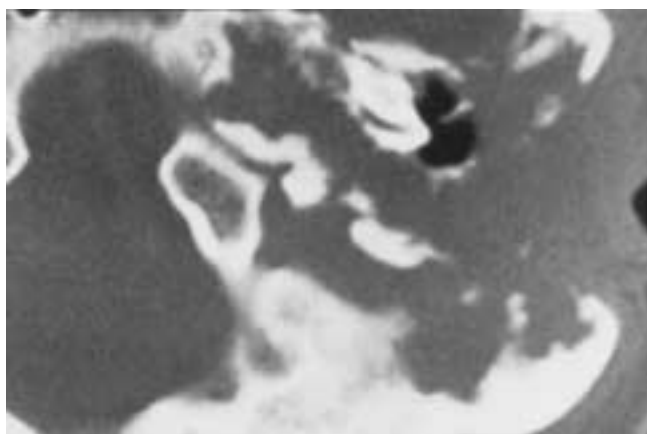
Eosinophilic granuloma. CT. The lesion is generally poorly defined, suggesting a moderately rapid growth rate. There is erosion of the otic capsule. (Courtesy of Dr. Roy A. Holliday.)
